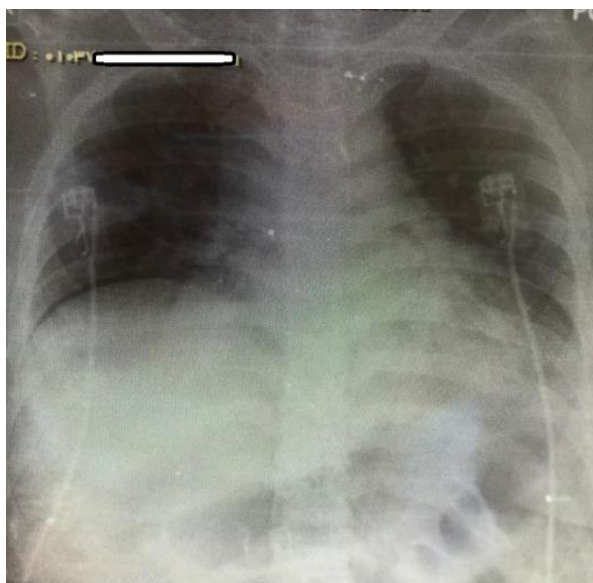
Posteroanterior chest radiograph of the patient.
